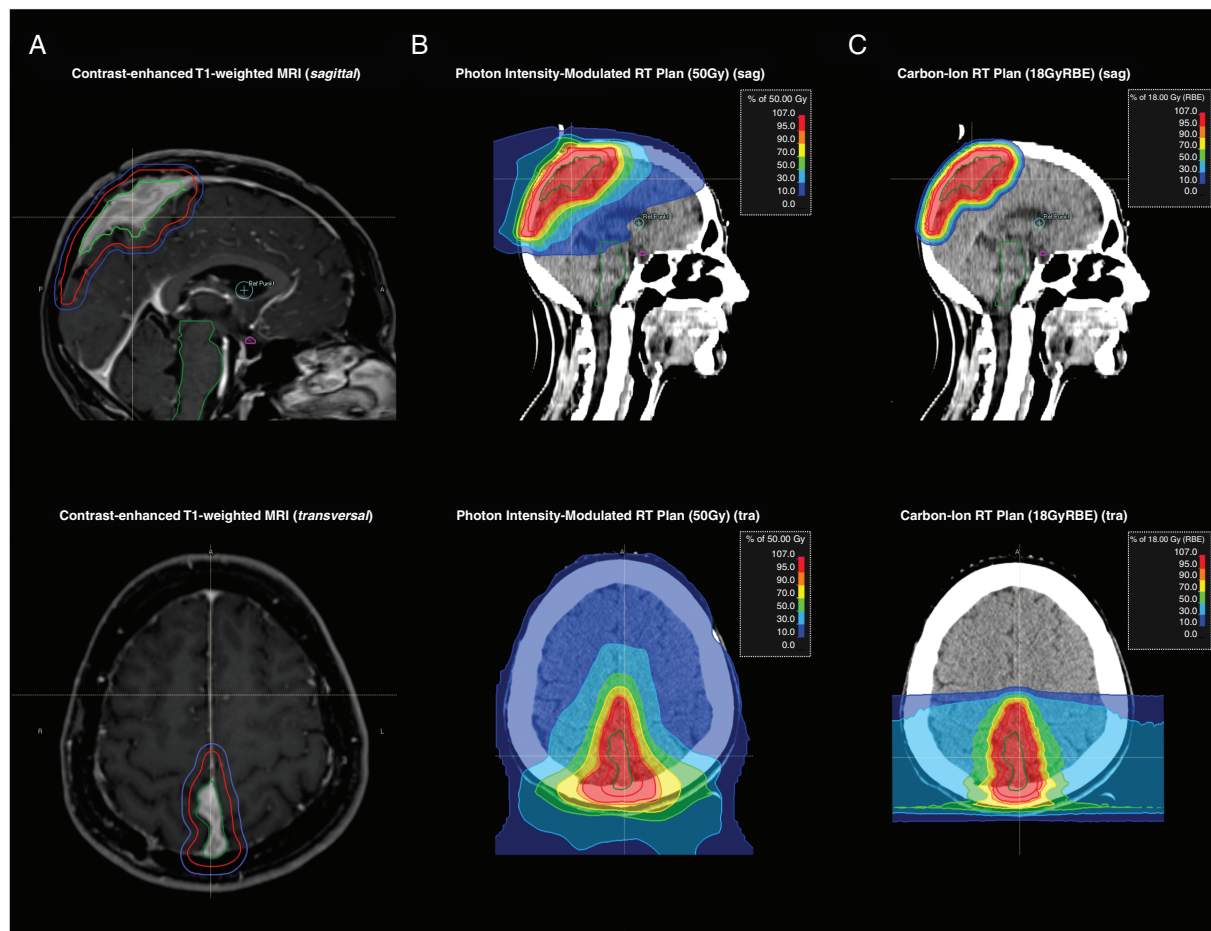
Exemplary photon and carbon-ion treatment plan for study patient MARCIE-33. (A) Visible macroscopic residual tumor parafalcine on contrast-enhanced T1-weighted MRI. The circled lines represent gross total volume (GTV) in green, clinical target volume (CTV2) in red, and the planning target volume in blue (PTV2) for the carbon ion boost. The dose distribution of the photon treatment plan (total dose of 50 Gy in 25 fractions) (B) and the carbon-ion boost (total dose of 18 Gy RBE in 6 fractions) (C) are shown with colored zones indicating the dose range in the surrounding brain parenchyma and skull.
